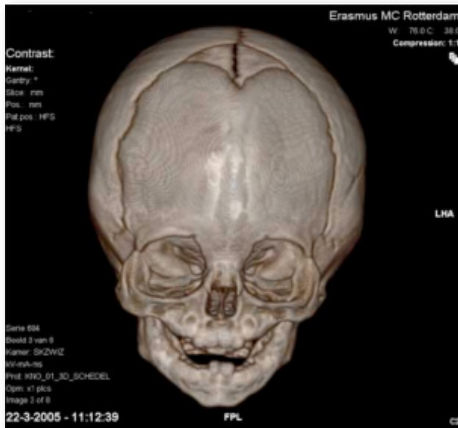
Preoperative 3D CT scan showing typical wedged forehead and hypotelorism.
